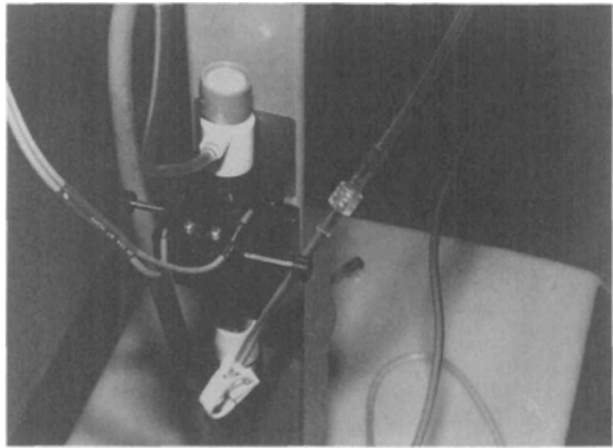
The ultrasonic air detector must be located above the level of the filter element of the filter/air eliminator, so that no solid objects reflect the ultrasound. To prevent the weight of the sensor from pulling the filter/air eliminator out of its housing, a strap or tape can secure the filter/air eliminator to the vertical support.
